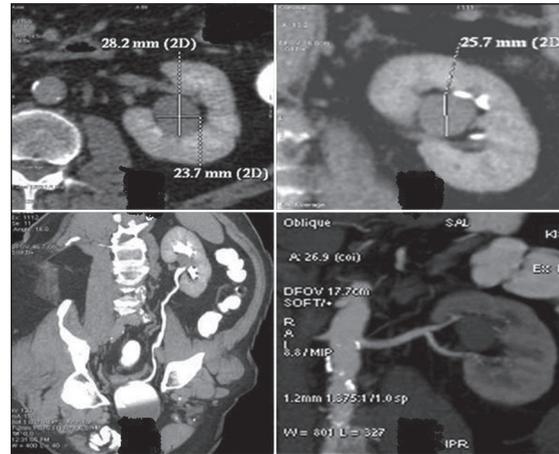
CT angiography helps in assessing the feasibility and approach to the mass
